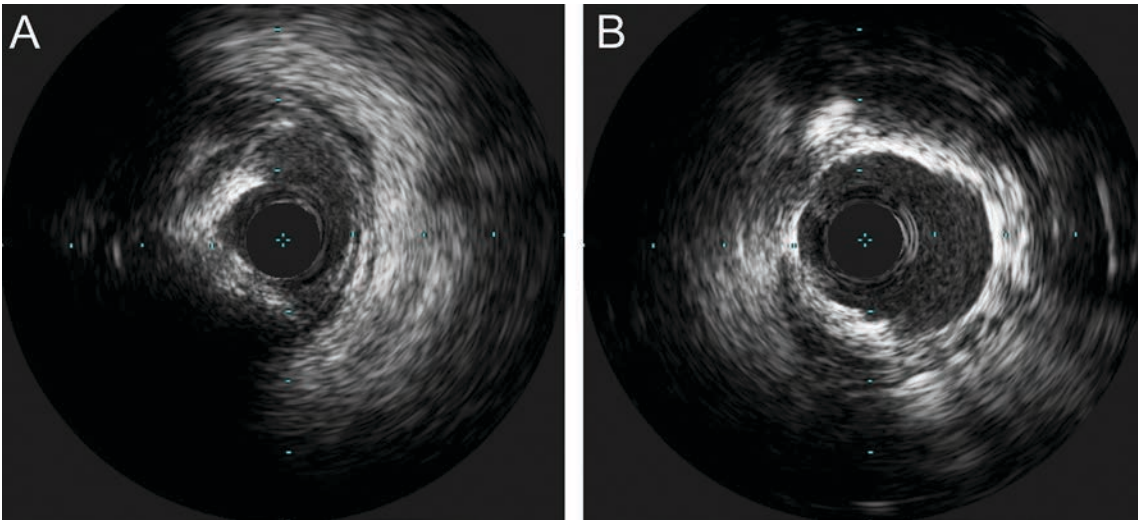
Intravascular ultrasound demonstrated severe disease of the proximal RCA with deep calcification (A). After further vessel preparation with a cutting balloon, stents were deployed and post dilated, yielding excellent expansion (B).
